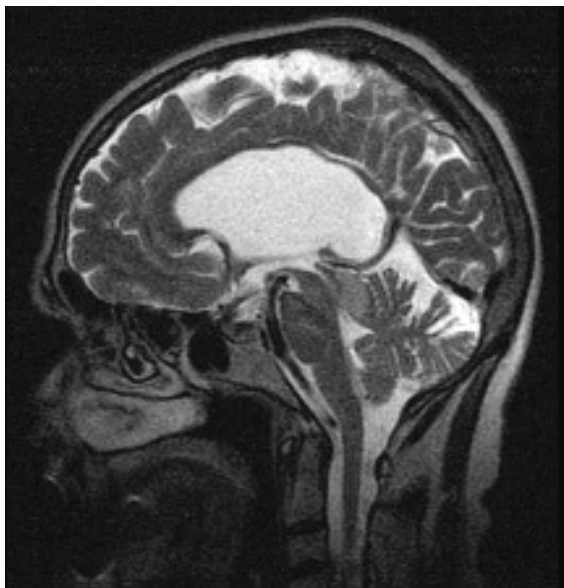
Cerebral MRI – Agenesis of the septum pellucidum
